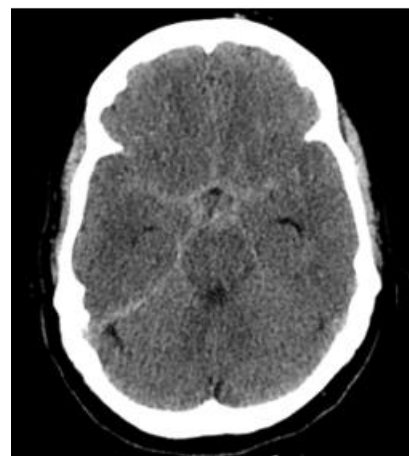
Plain CT Brain on 11/04/2026 – diffuse subarachnoid haemorrhage in basal cisterns.
